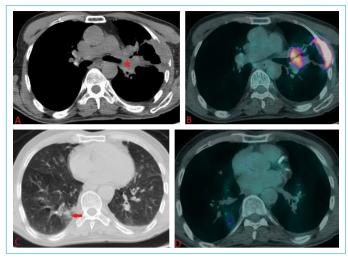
A 74-year-old male with lung cancer. (a) Axial non-contrast chest CT shows a mass in the left lung upper lob (star). (b) PET CT shows increased [¹⁸F]FDG uptake in the mass. (c) CT shows unilateral, ground-glass infiltrates with well-defined borders, predominantly peripheral and localized in right lower lobe (arrow). (d) In this area, PET CT shows increased [¹⁸F]FDG uptake (SUV max 4.9).
